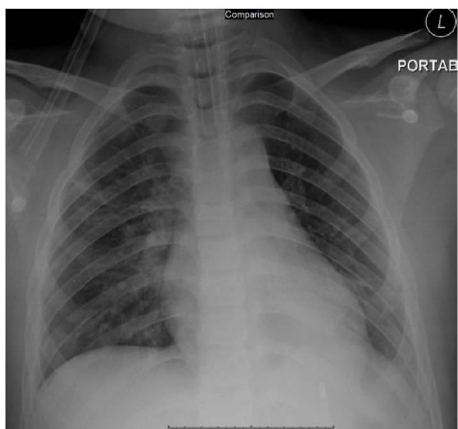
Chest radiograph post-bronchoscopy showed improvement of the air trapping in the left hemithorax evidence by reduction of the hyperlucency. There is also increase aeration of the left lower lobe. Consolidative changes in the perihilar region of bilateral lower and middle zones.
